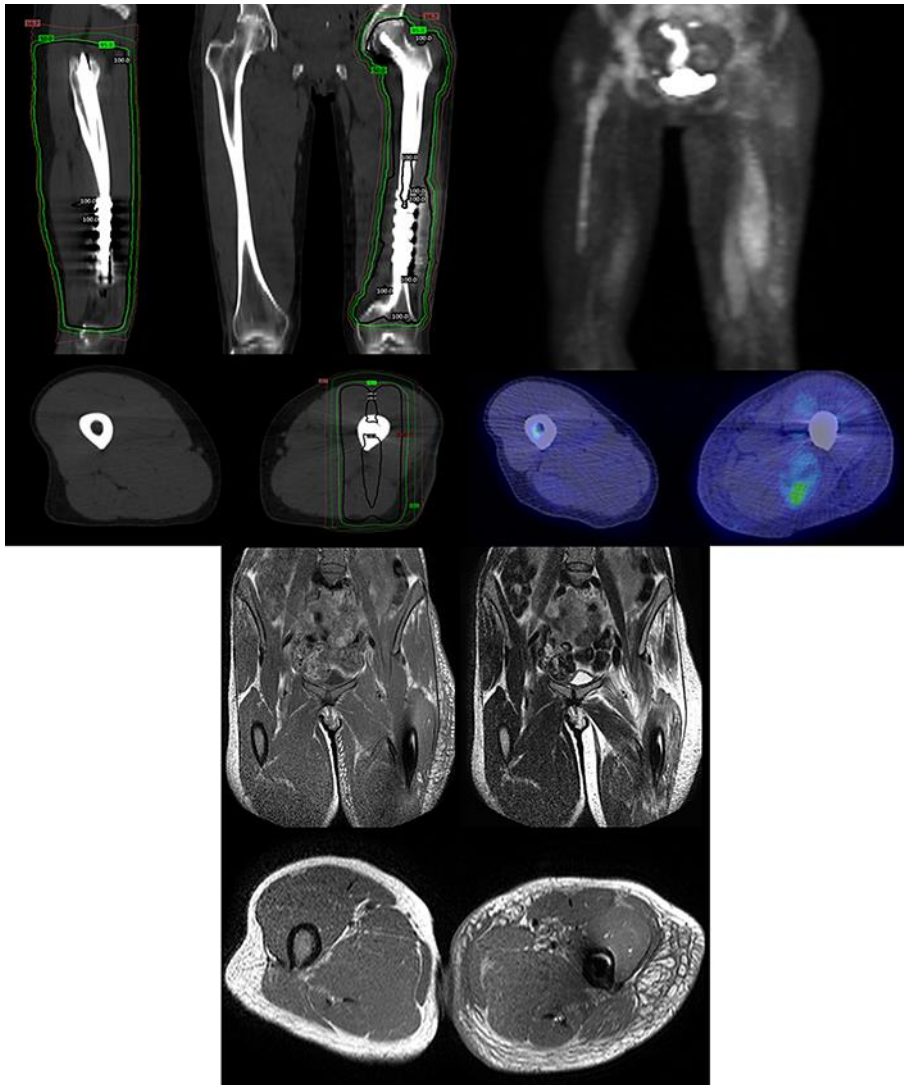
Top left: radiation fields of the left femur, with sagittal (top left), coronal (top right), and axial (bottom) views. The isodose levels shown are 16.7, 50, 95, and 100%. Top right: PET/CT showing edema and increased FDG uptake of the left thigh, consistent with myositis, with front-facing 3D (top) and axial (bottom) views. Bottom: MRI showing edema of the left thigh, consistent with myositis, with T1-weighted coronal images (top left), T2-weighted coronal images (top right), and T1-weighted axial images (bottom).
